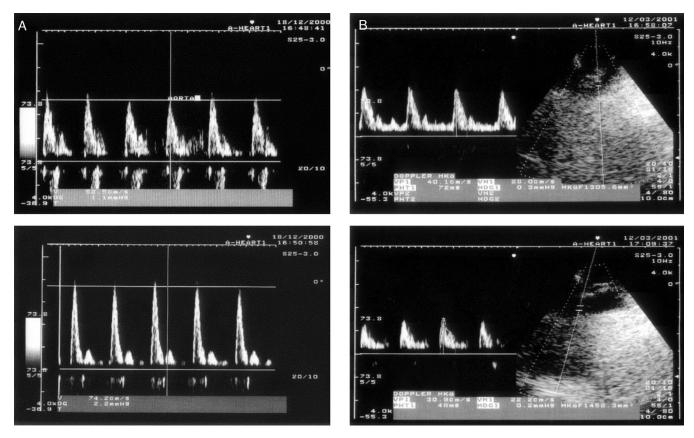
Case study: pw-Doppler imaging (brachiocephalic trunk) of a healthy subject (a) and a patient with severe systolic heart failure (b) in upright position outside of water (top part) and on immersion up to the neck (bottom part). In the healthy subject with immersion, the peak velocity increases from 49 to 76 cm \cdot s⁻¹, indicating an increase of stroke volume. In the CHF patient with immersion, the peak velocity diminishes from 40 to 31 cm \cdot s⁻¹, indicating a decrease of the stroke volume.
